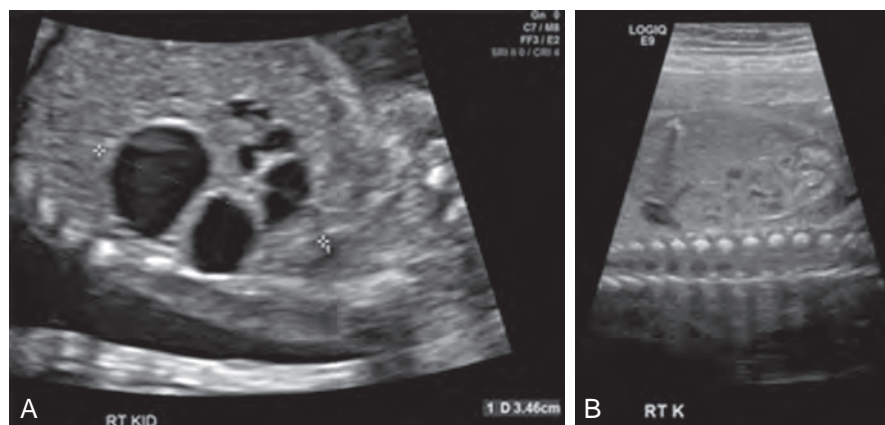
A, Prenatal sonogram demonstrating randomly distributed cortical cysts typically seen in multicystic dysplastic kidneys. B, Prenatal sonogram demonstrating homogeneously hyperechoic renal parenchyma of autosomal recessive kidney disease.
